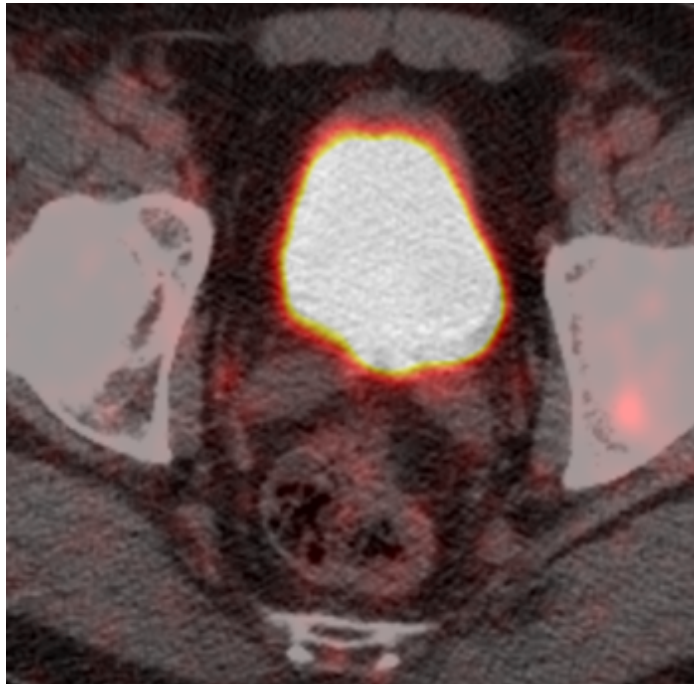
A PSMA-PET scan showing uptake consistent with a bone metastasis. This image is from the Addenbrooke's Hospital Data Collection.
